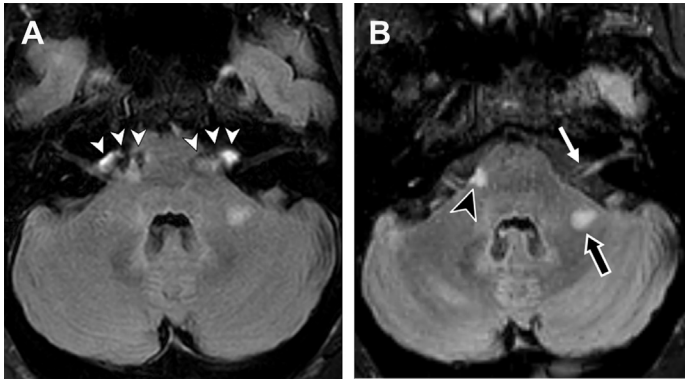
On 2D FLAIR (A), prominent CSF pulsation artifacts are seen in the cerebellopontine angles (*white arrowheads*), obscuring a demyelinating lesion in the right lateral aspect of the pons, which becomes visible on 3D FLAIR (B, *black arrowhead*). With 3D acquisition the fluid attenuation in cerebellopontine cisterns is homogeneous, allowing sharp visualization of not only the pons, but the 7th and 8th cranial nerves as well (B, *white arrow*). A second lesion is seen in the middle cerebellar peduncle on the right, which is also more conspicuous on 3D (B, *black arrow*).
